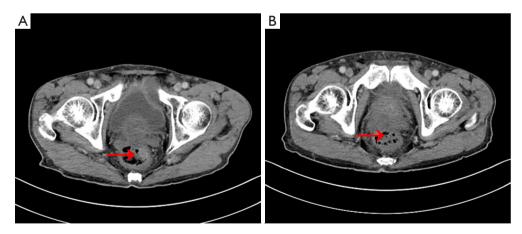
CT images in previous follow-up. A small high-density shadow inside the rectal wall (arrow) could be observed on CT images in November 2017 (A) but not in the images from September 2017 (B). CT, computed tomography.
